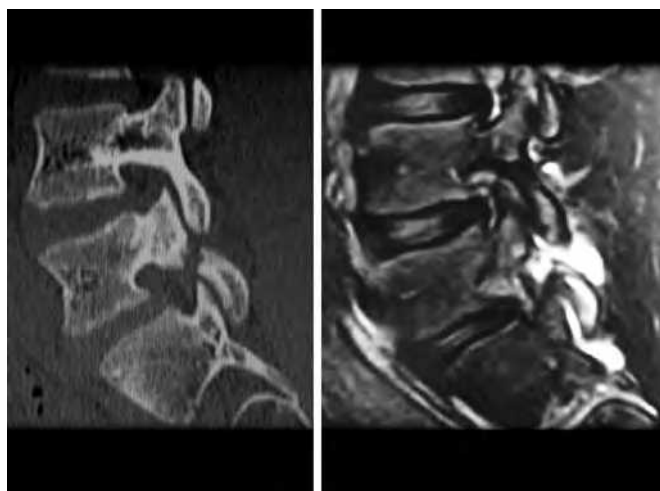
Computed tomography showing terminal-stage bilateral L5 spondylolysis. Short T1 inversion recovery—magnetic resonance imaging of a 14-year-old male soccer player clearly indicating effusion at the defect and both adjoining facet joints.
